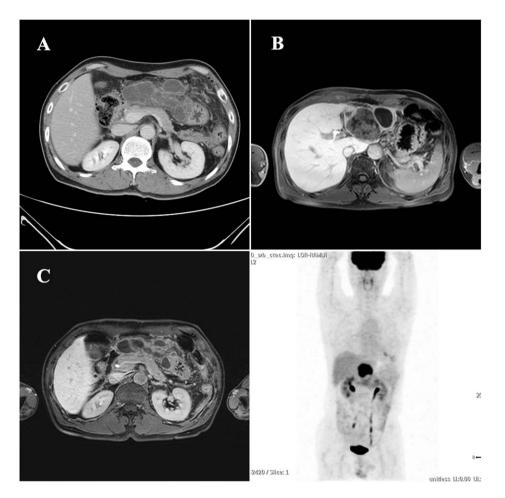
(A) Contrast-enhanced CT image showed multicystic conglomerated mass around lesser sac. (B, C) Magnetic resonance images revealed the oval mass containing innumerable frond-like papillary tumors and fluid in the lateral segment of the left hepatic lobe. Bile ducts were not dilated evidently. (D) PET/CT scans showed increased uptake of the left lobe of the liver.
